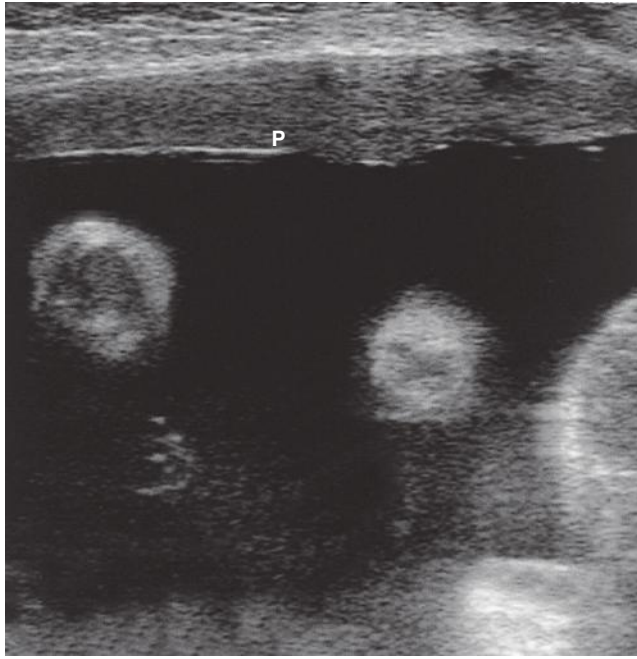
Sonogram in a patient with marked polyhydramnios. The placenta (P) becomes thin as the uterus expands from the increased amniotic fluid volume.
